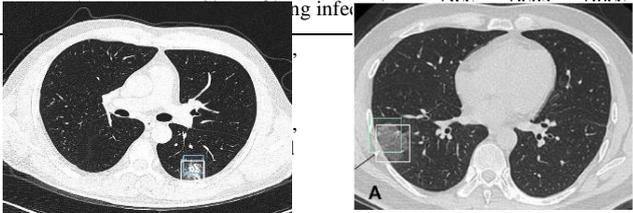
The object detection in CT images results with two conditions infected lesion by SARS-CoV-2 and healthy.
